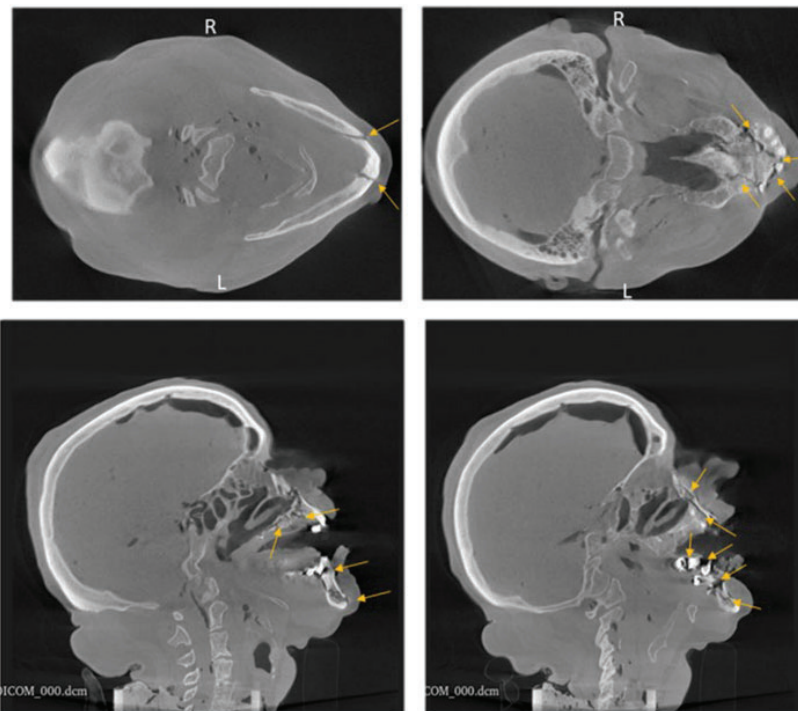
Post-test μ CT of PMHS in axial (top) and sagittal (bottom) planes showing damage to the mandible and maxilla for an off-centre mandible shot (BMP_04)
